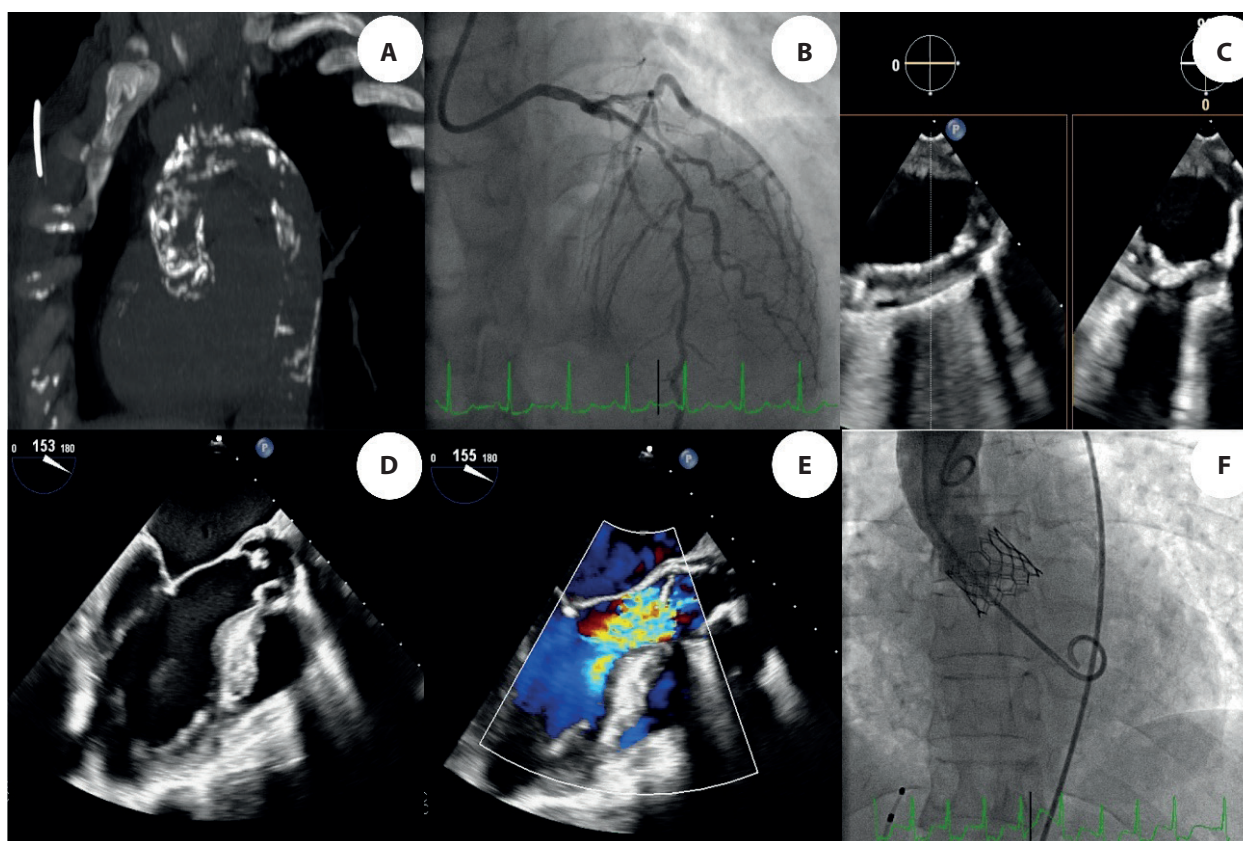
A. Computed tomography angiography showing massive calcification of the ascending thoracic aorta. B. Coronary angiography with diffuse and significant stenosis in the proximal/mid left anterior descending artery. C–E. Transesophageal echocardiogram showing calcified descending aorta (C) and aortic valve (D) and severe aortic regurgitation (E). F. Aortography showing TAVI in a patient with Tangier disease
